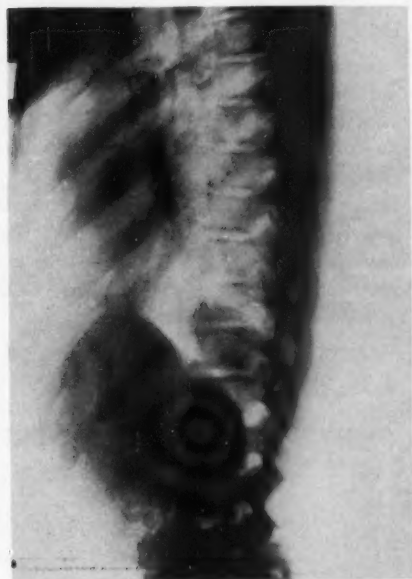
Roentgenogram of spine, Case 1, showing changes in upper lumbar spine secondary to irradiation.
